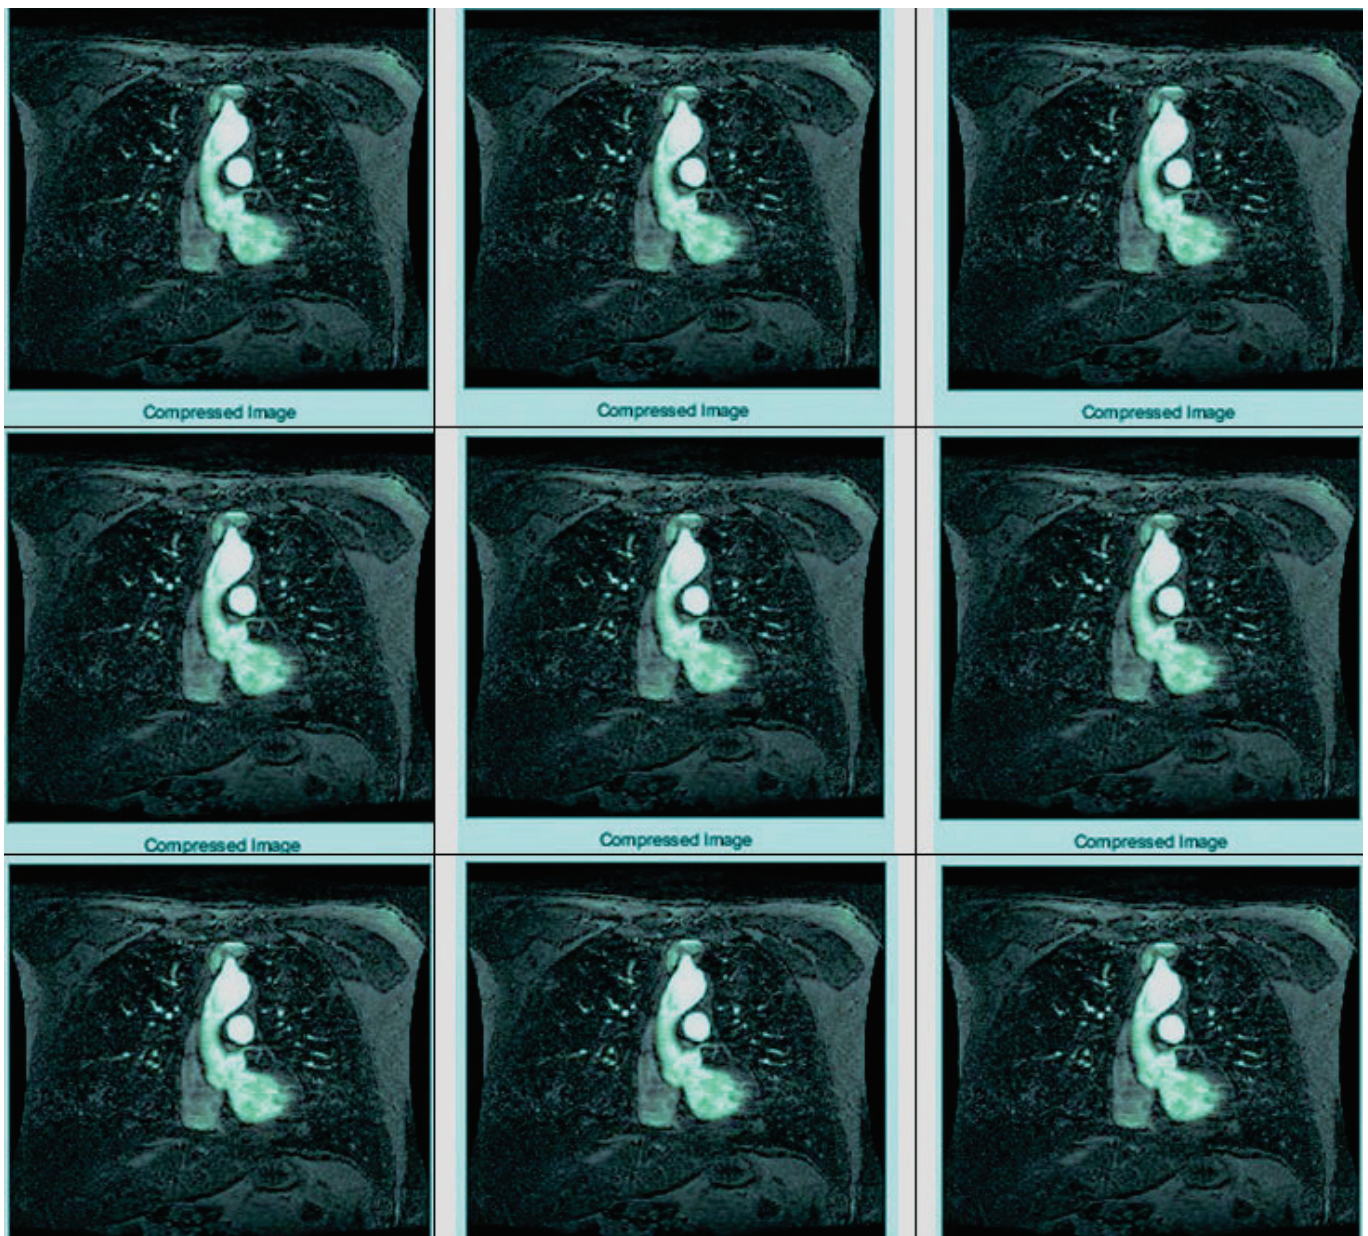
Multiple compression of MRI using different wavelet families.
